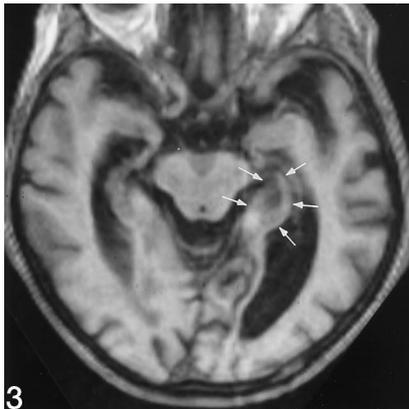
Reverse-angle axial T1-weighted (550/20) MR image in a woman with clinical AD (GDS score = 5). Note decreased signal intensity between the temporal horns and the perimesencephalic cistern (arrows), representing dilatation of the PHFs and atrophy of the structures of the medial temporal lobe, including the hippocampus. The size of the PHFs was assessed as moderately dilated.
